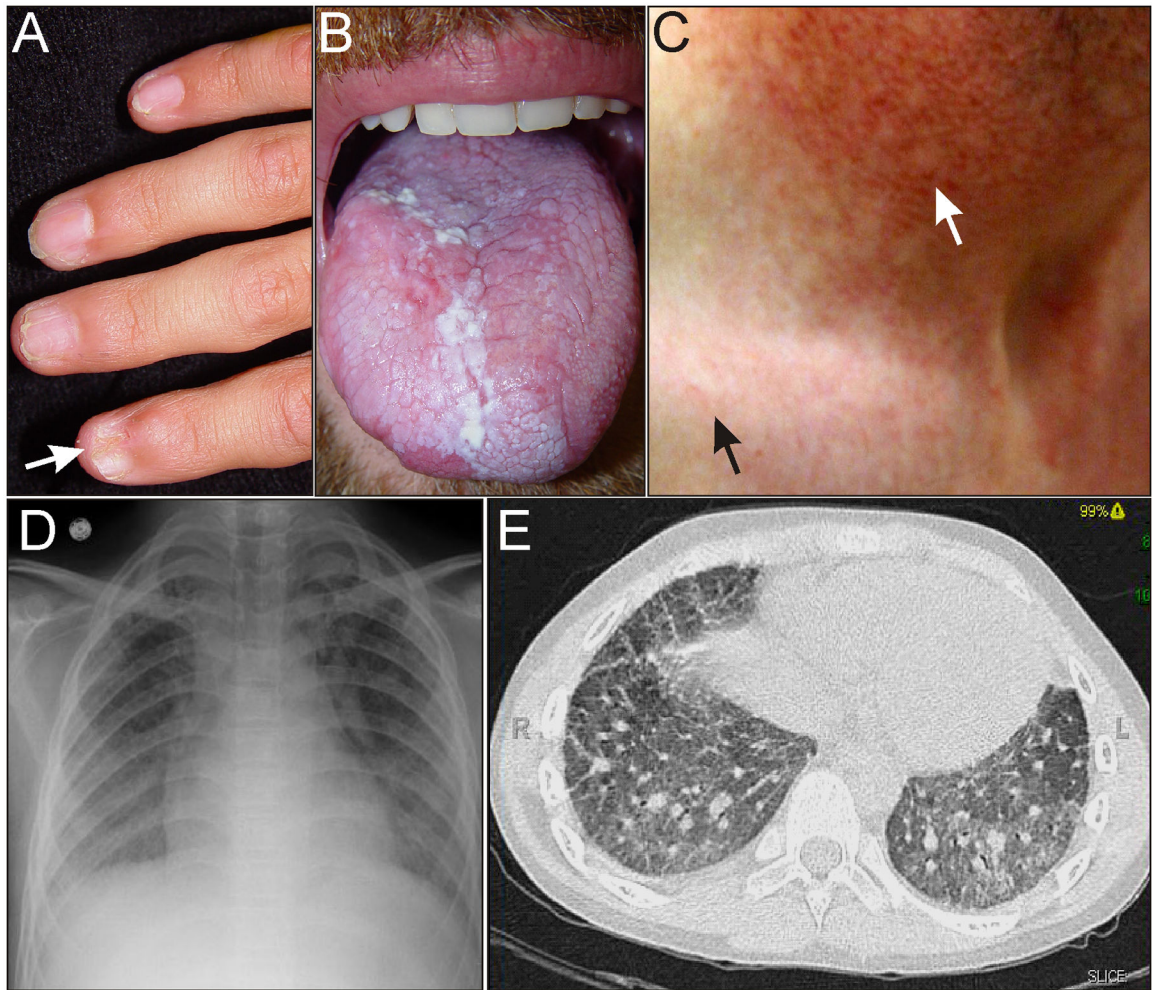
Phenotypic features of DC. (A) Nail dystrophy (arrow) in an adolescent. (B) Oral leukoplakia in an adult. (C) Skin changes in an adult. Hypopigmented lesions and the typical reticular rash of DC are evident on the upper chest (black arrow). Hypopigmentation is more pronounced in the sun-damaged skin of the neck (white arrow). (D,E) Pulmonary fibrosis on chest radiograph and CT scan of an adult. Photographs courtesy of Susan J. Bayliss, M.D. and William H. McAlister, M.D.
